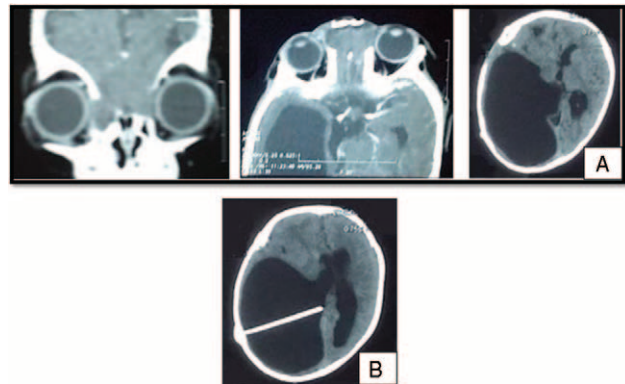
Computed tomography (CT) brain showing frontobasal bone defect and hydrocephalus. (A) Preoperative CT brain (coronal and axial cuts) showing frontobasal bone defect and hydrocephalus. (B) Postoperative axial CT scan with right v-p shunt.
